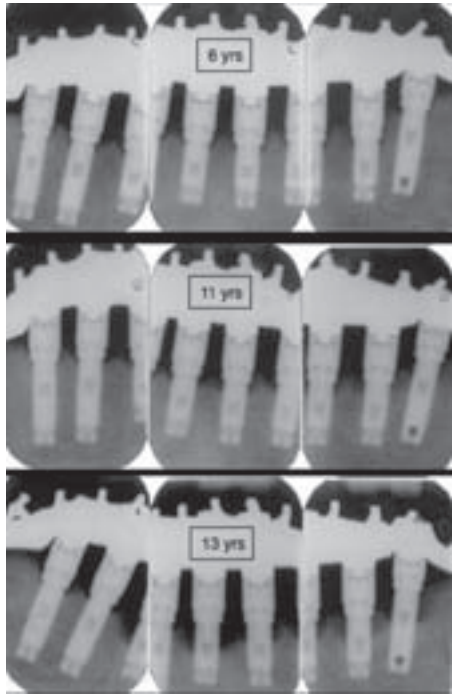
Longitudinal radiographic documentation of developing peri-implantitis. Moderate bone loss after 11 and advanced bone loss after 13 years of function compared with 6 years after implant installation. In a recent study, 27.4% of the patients experienced peri-implantitis in 12.4% of the implants. (Adapted from Fransson *et al.* (44)).
